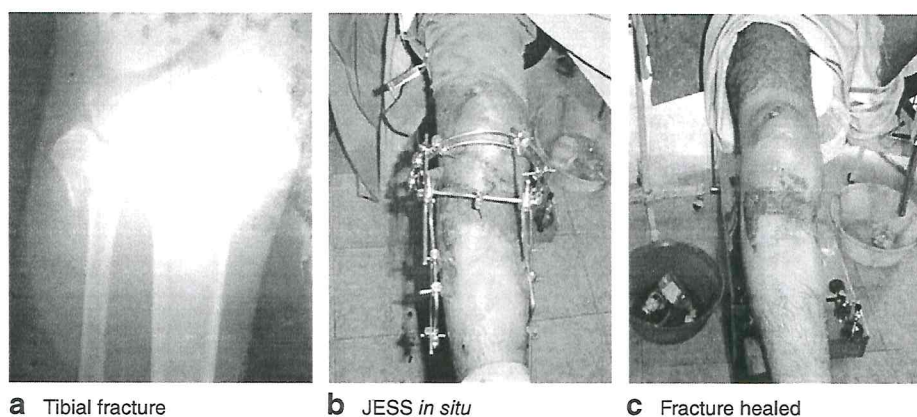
Joshi's external stabilization system (JESS) stabilizing a tibial fracture. a Radiograph of tibial fracture; b JESS device *in situ*; c JESS removed and fracture healed. Reproduced with permission from J. Gnanaraj; photograph credit to R. Prabhoo
